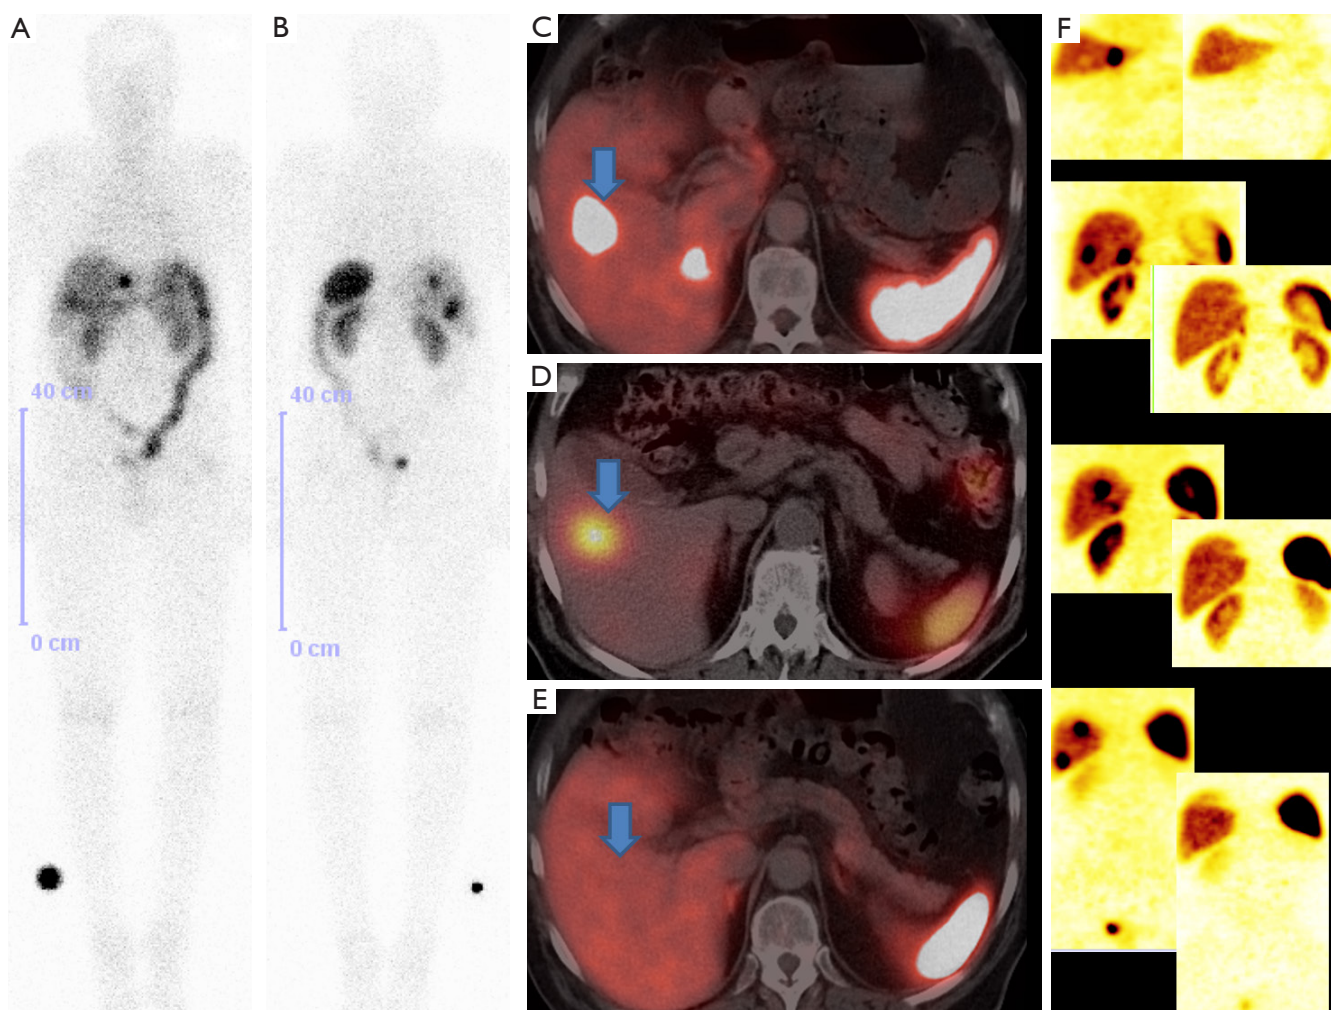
Intense uptake is present in liver metastases as well as in the primary tumor (demonstrated on the post-therapy whole-body scans after the 2nd PRRT cycle, A and B, respectively in anterior and posterior views). The target lesion in segment 8/5 of the liver (arrows) with an SUV of 29.7 (seen in C, fused transverse Ga-68 SSTR PET/CT pre-therapy) also received a very high absorbed radiation dose of more than 300 Gy (as demonstrated by the intense uptake seen on the fused SPECT/CT in transverse view after Lu-177 DOTATOC therapy, D). PRRT resulted in complete remission of this lesion (seen on the post-therapy SSTR PET/CT, E). Panel F exhibits a comparison between the coronal slices of SSTR PET before (left) and after (right) PRRT, indicating excellent therapy response.
